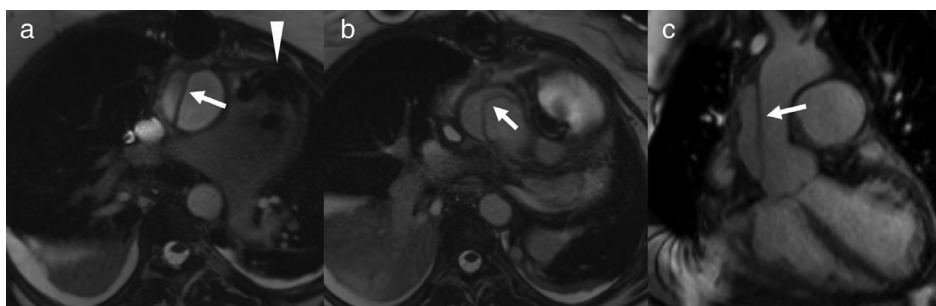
bSSFP MRI of aortic dissection in a 54-year-old woman shortly after pulmonic valve replacement for pulmonic insufficiency related to congenital rubella. Sequential single-shot bSSFP MR images (a,b, respectively) demonstrate a dissection flap within the ascending aorta which extends into the aortic root (arrows), in keeping with Type A dissection. Oblique coronal single-shot bSSFP MR image (c) demonstrates the extent of the dissection (arrow). Note the signal loss at the pulmonic valve related to the prosthesis (arrowhead). She was treated surgically with ascending aortic graft repair.
